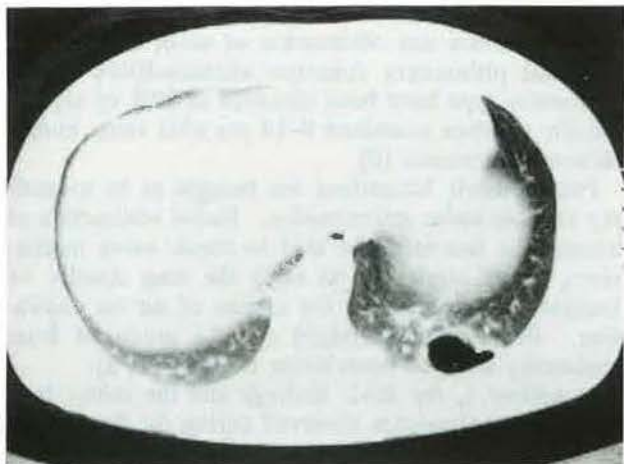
Computer tomography (CT) scan taken 1.5 months after the accident shows a cavity in the left lower lobe (patient 1).
